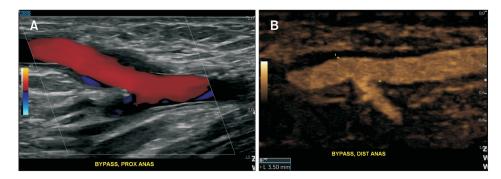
Duplex ultrasonography was performed 12 months after the operation. The patency of the entire graft from the proximal anastomosis (A) to the distal anastomosis (B) was maintained well without stenosis or occlusion.
